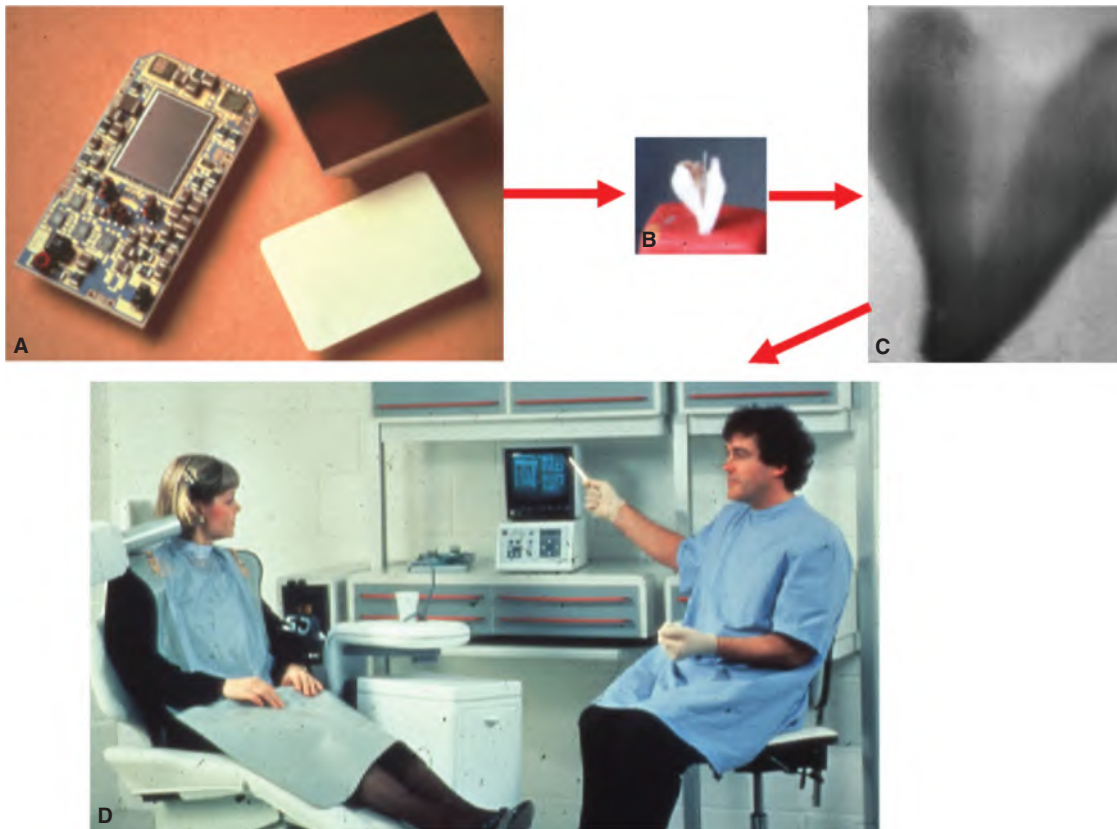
1 A. components of the RadioVisioGraphy (RVG)-32000 showing the solid-state electronics board with charge-coupled device (CCD) chip, the scintillator, and the fiber-optic plate used to reduce the size of the image to the size of the CCD. The fiber optics were made of tungsten glass that protected the CCD from direct exposure to X-rays; B. Primary tooth of Mouyen's daughter; C. The first "clinical" RVG image achieved in Dr. Mouyen's living room of this tooth; D. Commercial version of the RVG with Mouyen himself in the blue gown.
